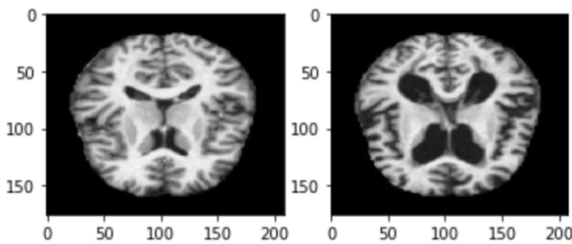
MRI Images from the Dataset at Different Heights in the Brain
